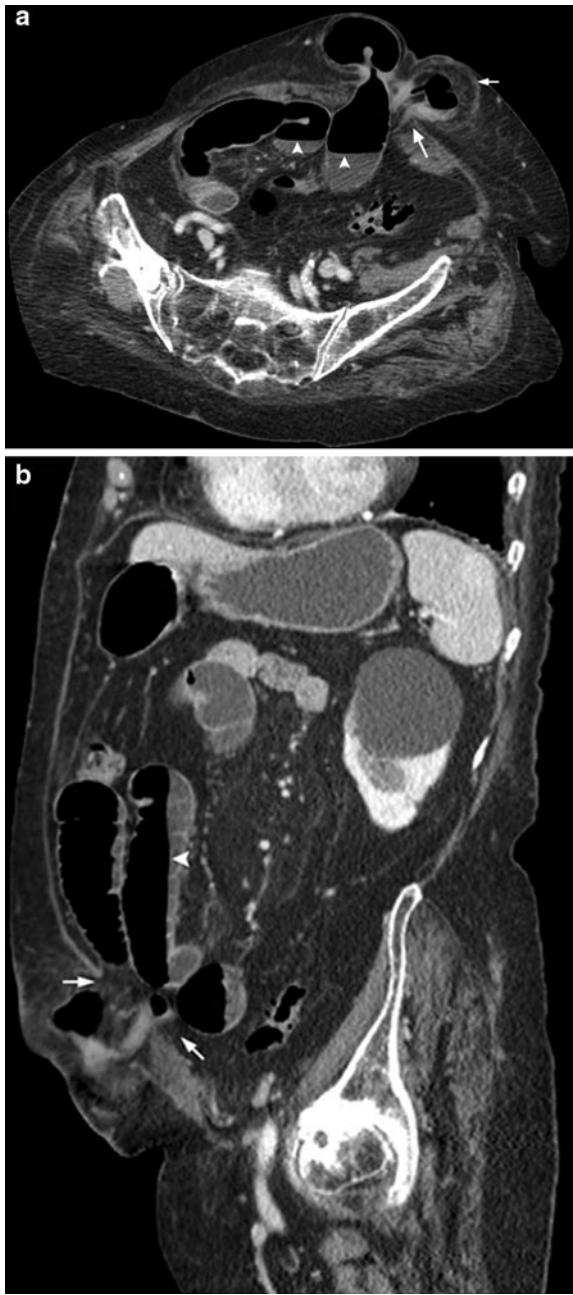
Hypogastric paramedial hernia in an 85-year-old woman who presented with abdominal distension. a, b Axial and sagittal contrast-enhanced reformatted CT images of the abdomen show a strangulated hernia (*arrows*) causing small bowel obstruction (*arrowheads*). A herniated bowel loop with a C-shaped configuration and fat stranding around the herniation are also seen. The sagittal contrast-enhanced reformatted CT image (b) of the abdomen more clearly demonstrates the amplitude of the wall defect (*thin arrows*), air–fluid levels, and dilatation of intra-abdominal bowel loops secondary to small bowel obstruction (*arrowhead*)
